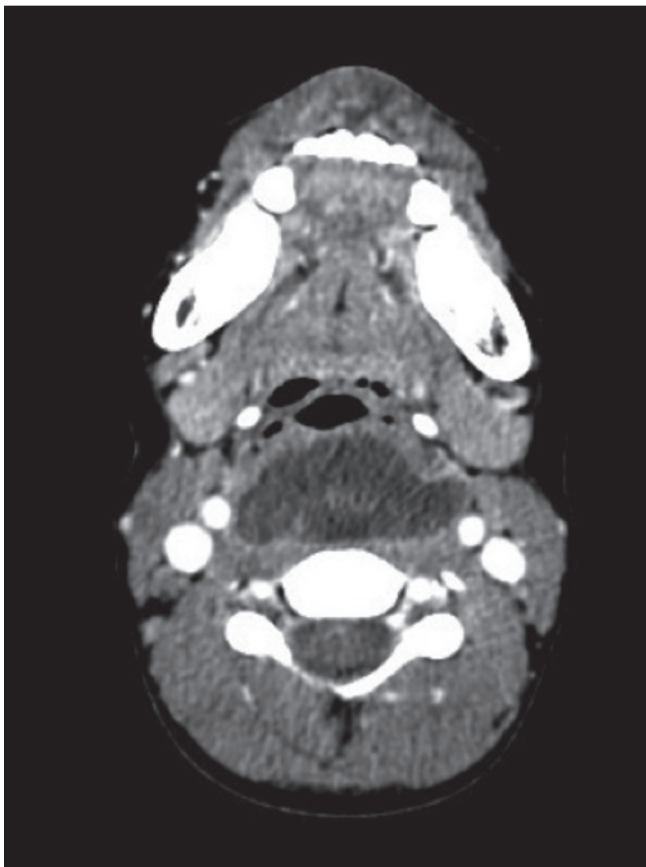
Contrast axial CT scan showing a well-defined low density soft tissue mass (retropharyngeal voluminous macrocystic LM) with an enhancing rim and multiple septations, causing significant narrowing of the supraglottic airway.
